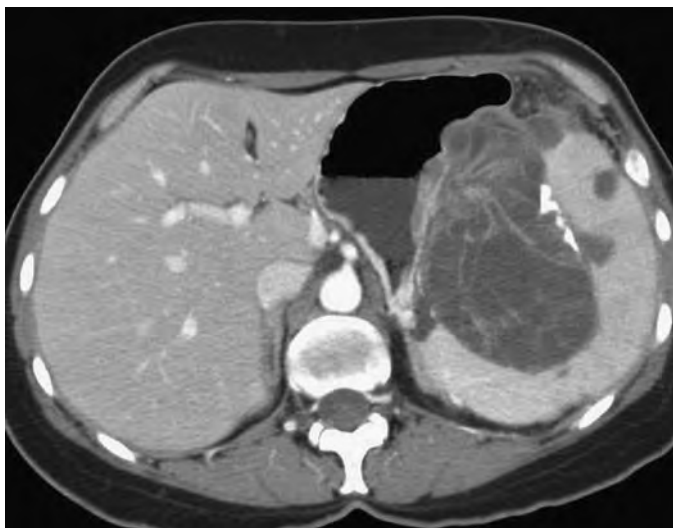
Direct invasion of the spleen by a pancreatic mucinous cystadenocarcinoma. In a 52-year-old woman, the enhanced CT scan of the upper abdomen demonstrates a septate cystic mass with some coarse calcifications involving the tail of the pancreas (not shown) that is invading and displacing the splenic hilum. A few small, hypodense lesions in the spleen are consistent with metastatic disease.
